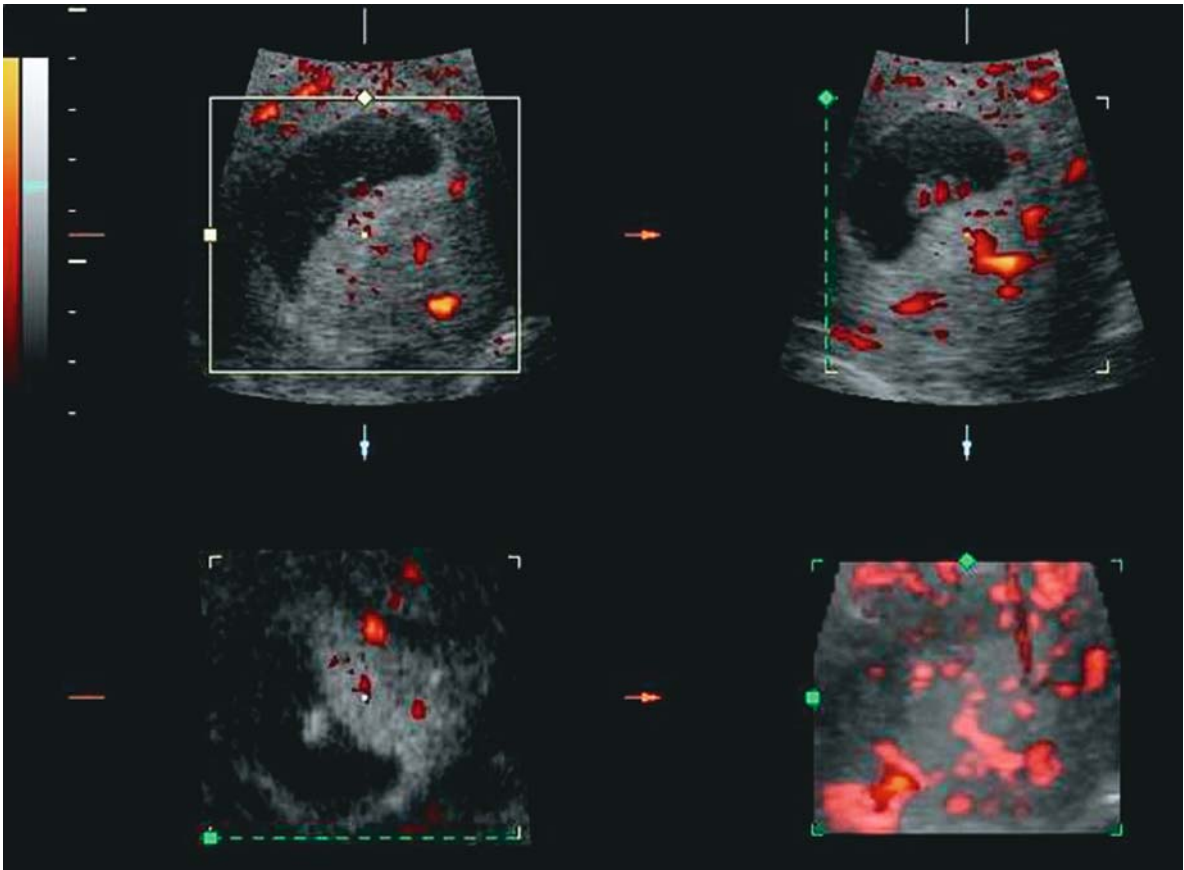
Tumoral vessels network in ovarian mass reconstructed by 3D Doppler
